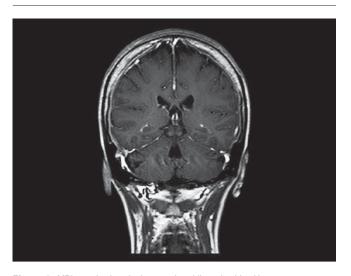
MRI examination: the images show bilateral epidural hematomas spreading from the bottom to the top of the brain with increased T1 relaxation time – methemoglobin phase – subacute hematoma. It is wider on the right (maximum width between 5 and 6 mm) whereas on the left the hemorrhaging area is smaller (from 3 to 4 mm). No mass effect is found.
